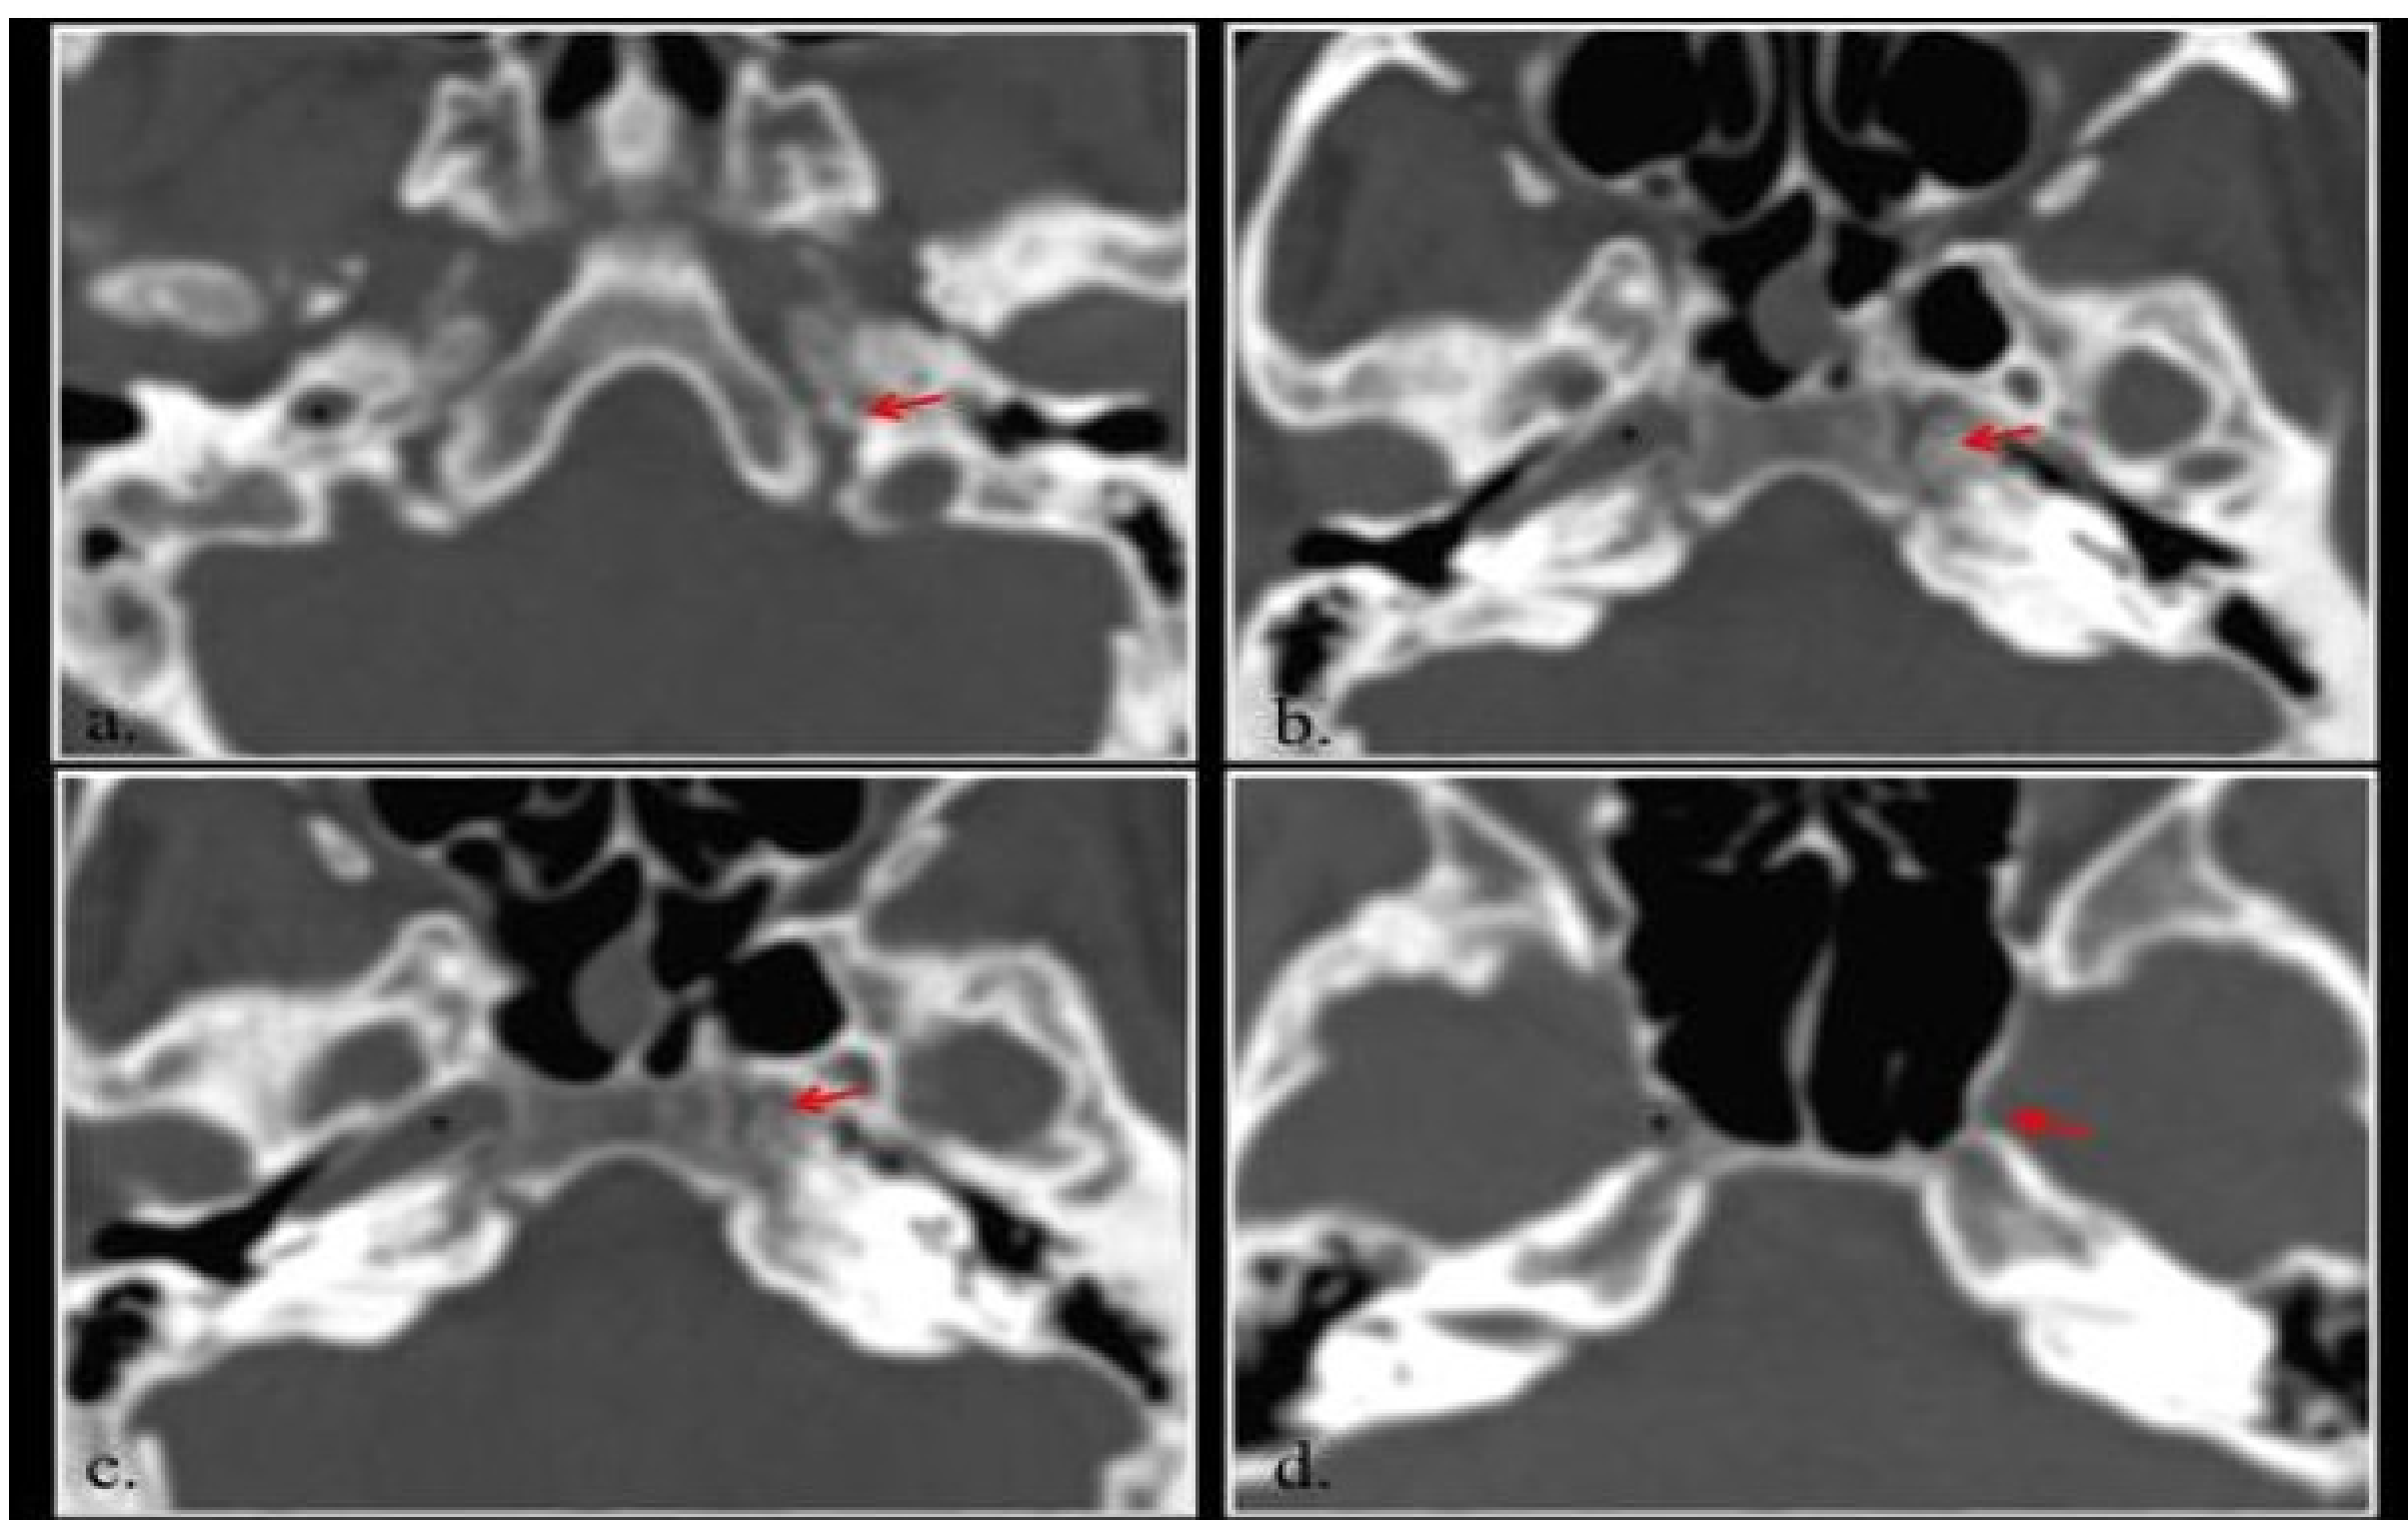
Axial Computed Tomography (CT scan) with bone algorithm.
